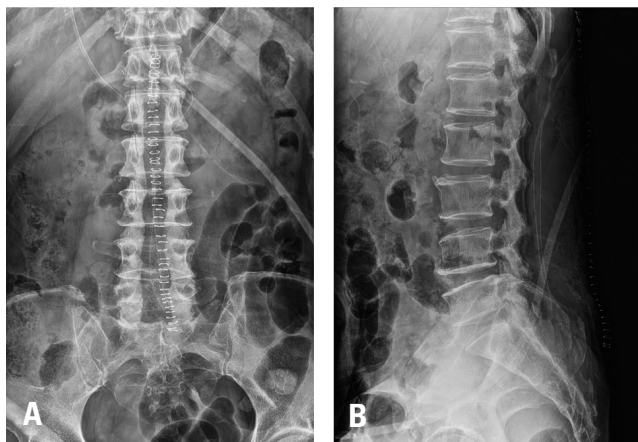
Postoperative lumbar spine radiographs. (A) Postoperative anteroposterior view and (B) lateral view. The radiographs show laminectomy from the first lumbar level to the first sacral level via the Gill procedure.
